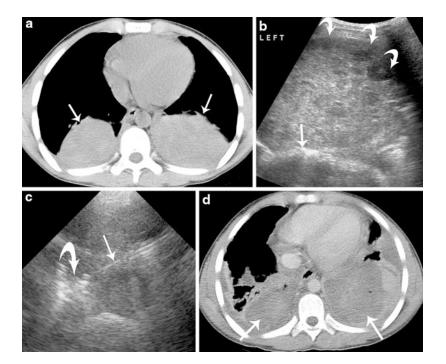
Twelve-year-old male undergoing palliative RFAfor bilateral pulmonary metastatic ostoesarcoma. (a) CT image of the chest demonstrating bilateral pulmonary metastatic lesions (*arrows*), measuring 5 cm (*right*) and 8 cm (*left*). (b) Sonogram of the osteosarcoma (*curved arrows*) adjacent to normal lung (*straight arrow*) prior to
